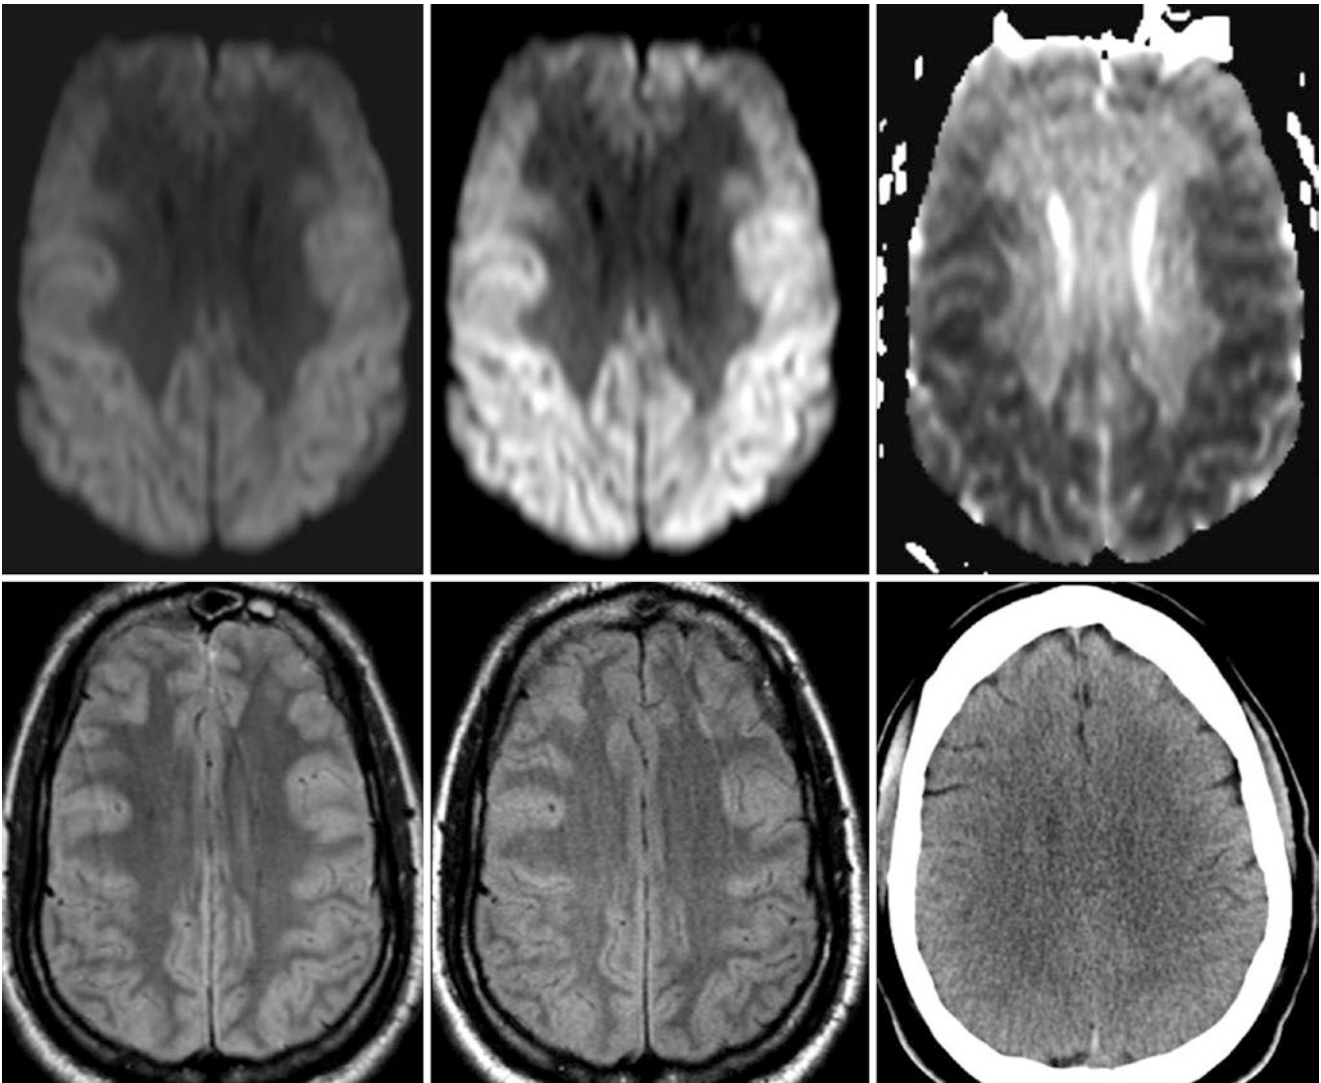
Comparison case of “superscan” on DWI in HIE. A 3 T MRI in a 19-year-old 3 days after he hung himself showed homogeneously hyperintense cerebral cortices on improperly windowed DWI (*top left*), representing a so-called DWI superscan (mistakenly called normal by the on-call resident). Optimized windowing (*top middle*)
